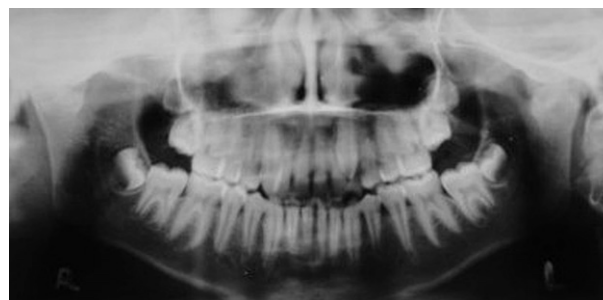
Preoperative orthopantomogram of patient with TMJ ankylosis.
